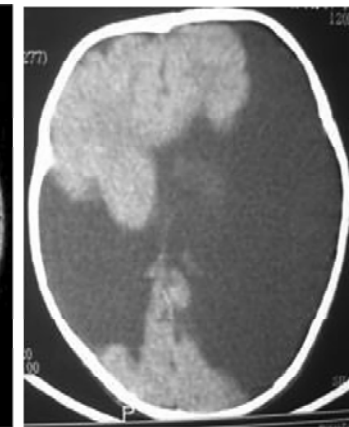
Plain CT brain showing bilateral schizencephaly
